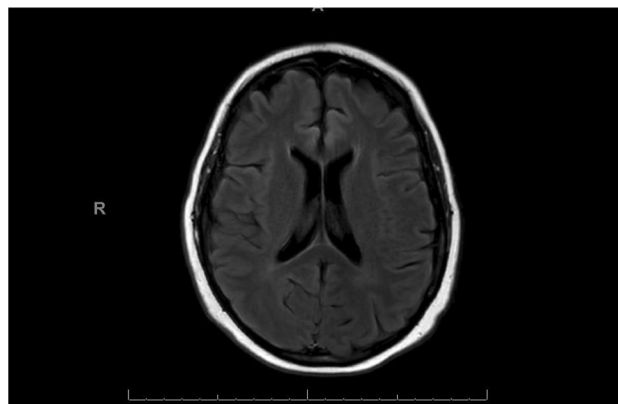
Axial section of MRI Brain FLAIR showing normal cerebral structures
